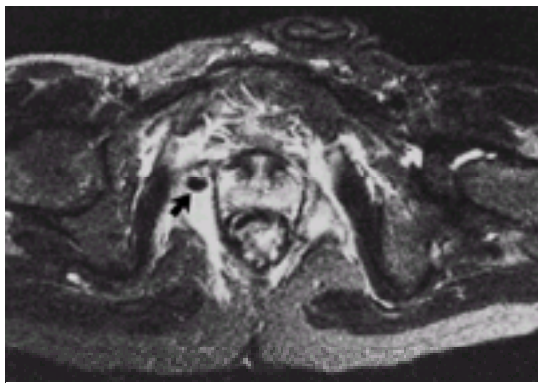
MRI scan of perineal area showing gas (arrowed) within an abscess cavity extending into the ischiorectal fossa.
